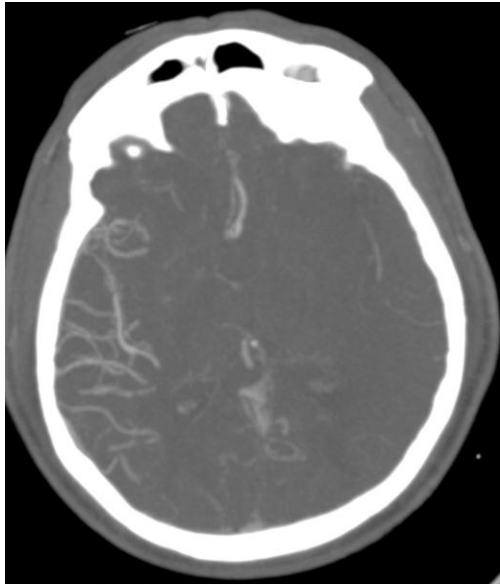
Axial CT MIP Del. Art. phase showing poor col. score (mASITN/SIR grade 1)
